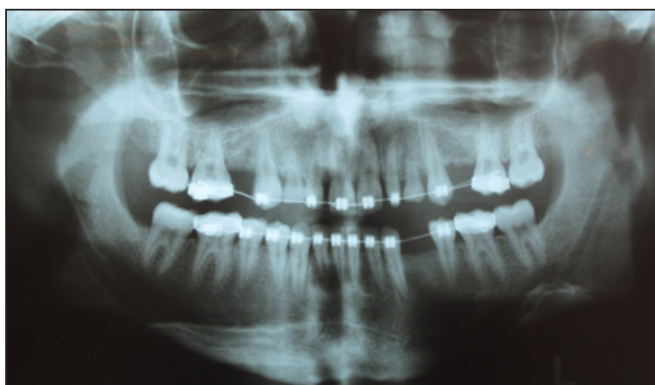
Radiographic view of teeth two months before laminate treatment.
